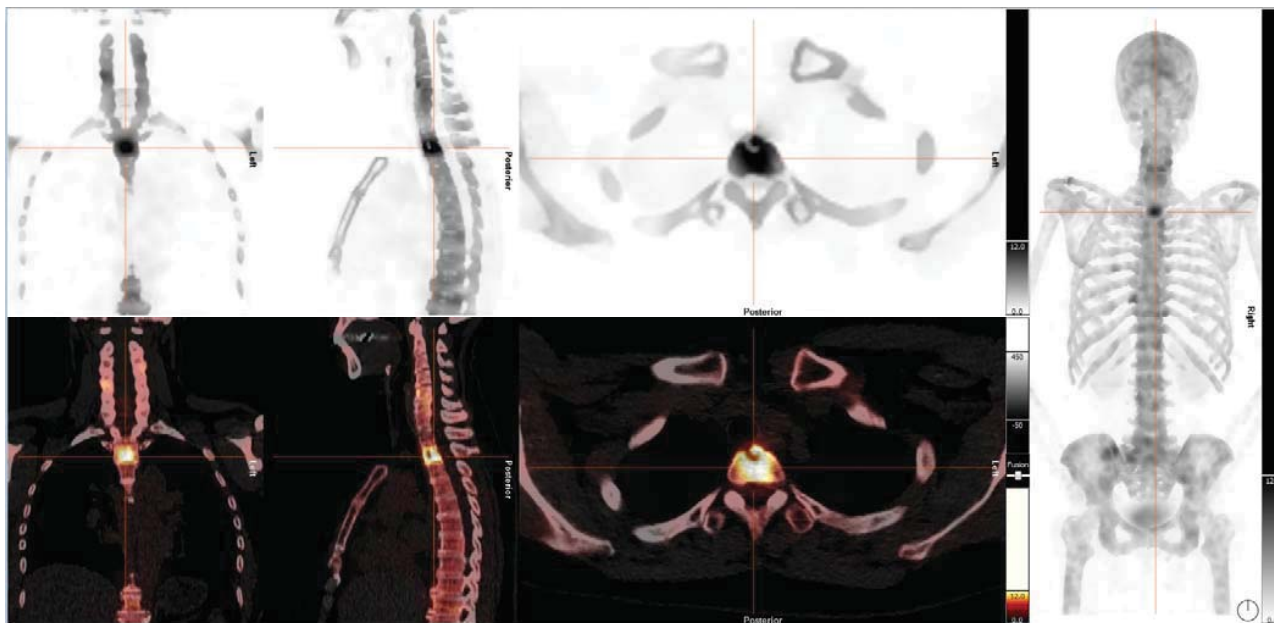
Case 4: SPECT images and SPECT/CT images (an example of a metastasis)
